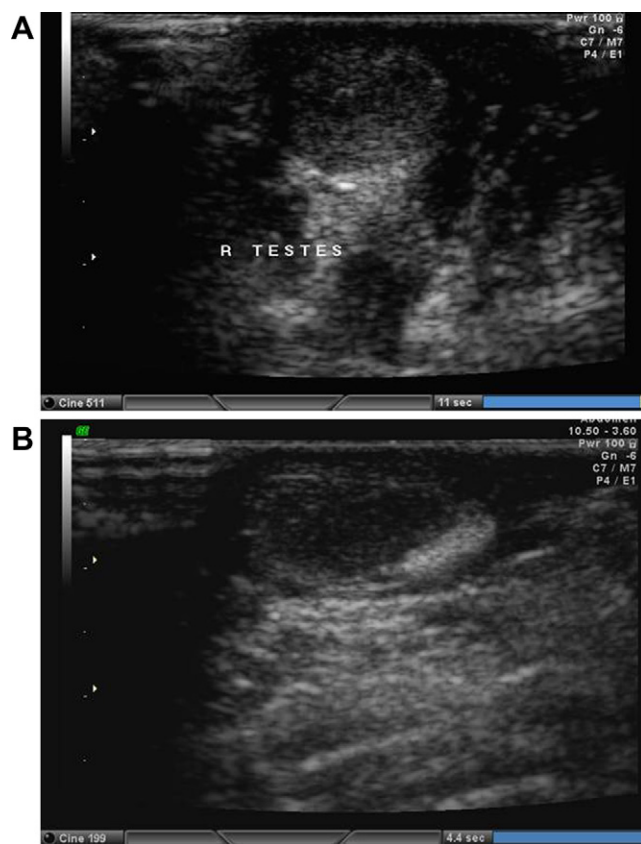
Ultrasonographic findings of bilateral small testicles with hyperechoic foci. (A) Right testis; (B) left testis.
